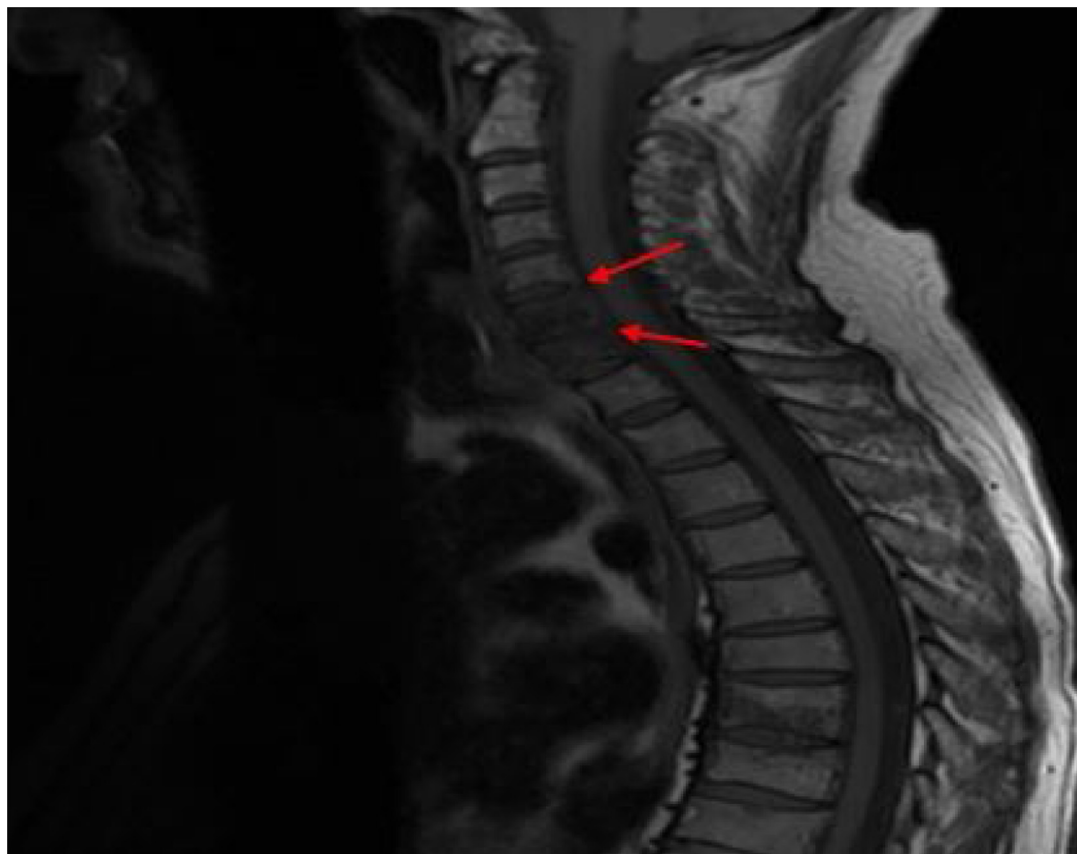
Control Sagittal cervical T1 weighted magnetic resonance imaging (MRI) showing significant improvement of the epidural collection.
